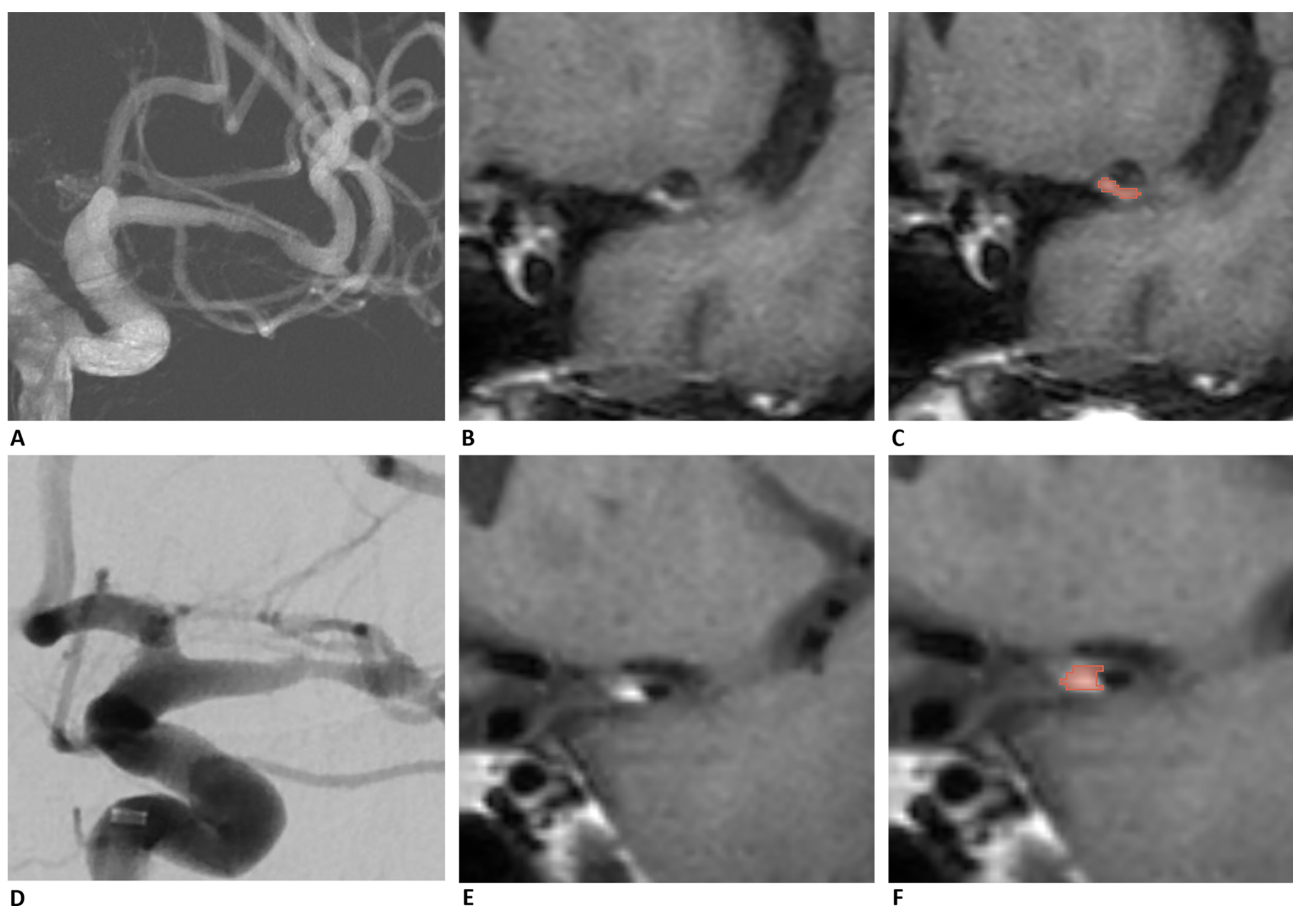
Two patients with different flatness values are presented in (A–C) and (D–F). Patient 1 (A–C) has a flatness value of 0.23, indicating that the plaque shape is relatively flat. In contrast, Patient 2 has a flatness value of 0.83, suggesting a more spherical plaque shape. Images (A) and (D) show the preoperative angiography of the stenosis site, confirming the location of the stenosis. Images (B) and (E) display plaques identified in HR-MRI, which appear as high signals in the black-blood sequence. Images (C) and (F) present the segmentations of the plaques from the two patients, highlighted in red. HR-MRI, high-resolution magnetic resonance imaging.
